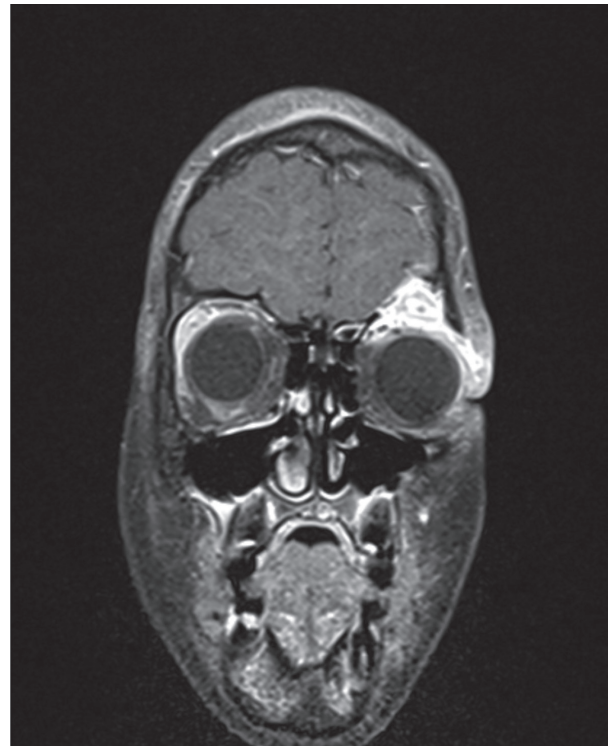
Coronal cut of Brain MRI showing superior orbital lesion
